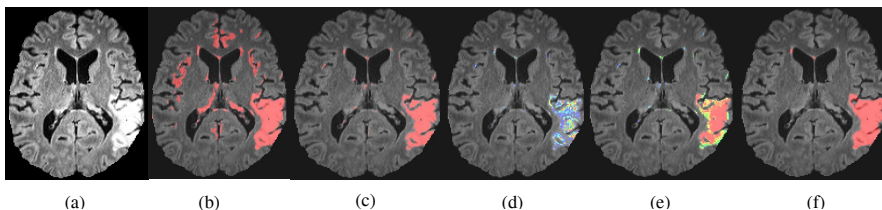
Effect of each stage of the proposed segmentation method (a) FLAIR image; (b) & (c) Possible lesions classes overlaid after 5- and 8-class MAP-MRF; (d) & (e) probabilities after 8-class EM and probabilities from RF (color range: blue=0, red=1); (f) Final binary classification of RF probabilities.
